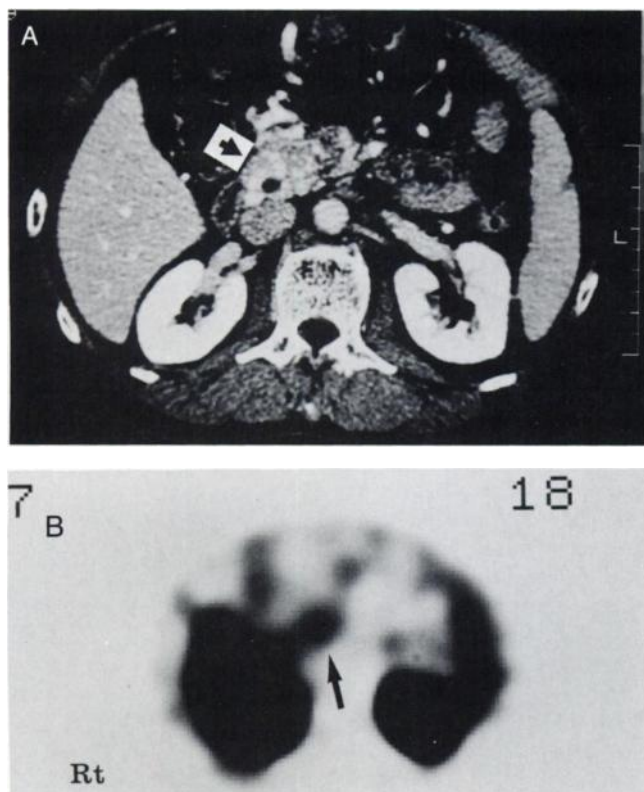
A 78-yr-old woman with a tubular adenocarcinoma. (A) Enhanced CT shows a low attenuated 30 × 30-mm tumor in the pancreas head (→). (B) Thallium-201 SPECT image shows intense uptake corresponding to the tumor, with an L/H ratio of 0.83 (→).
